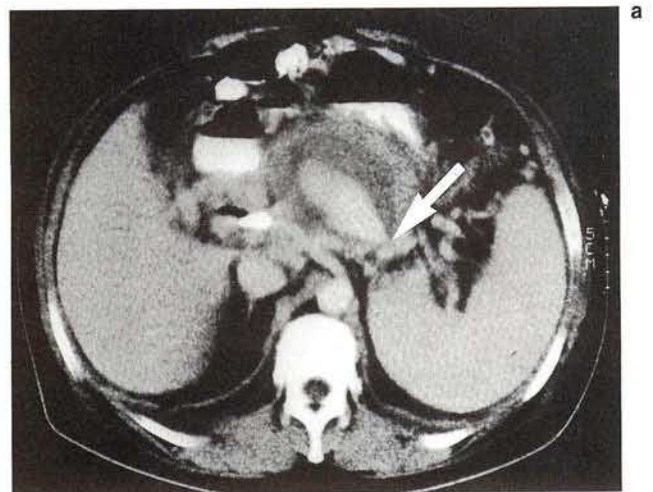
Spiral CT with intravenous contrast shows hemorrhage from the splenic artery into a pancreatic pseudocyst (a), which was confirmed by angiography (b). Arrow: blood leakage from the vessel.
